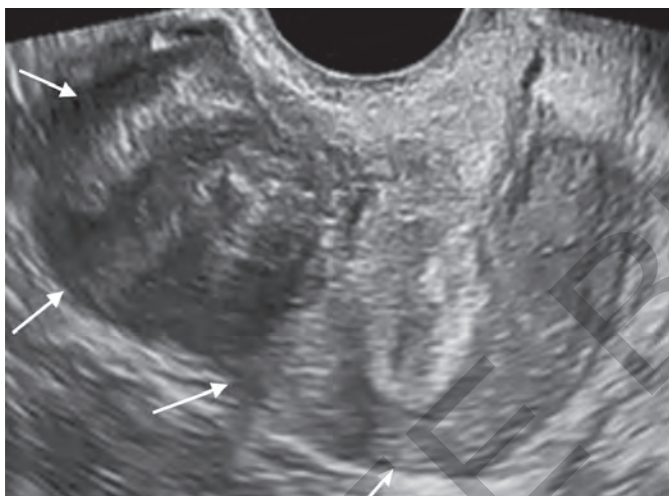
2D ultrasonography distorted serosal margin of the uterine wall due to subserosal fibroid (white arrows).
